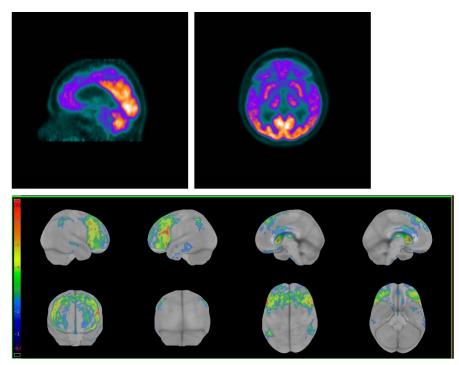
Metabolic pattern of amyotrophic lateral sclerosis on FDG-PET. Representative sagittal and axial PET images (upper pictures) show hypometabolism in the prefrontal and premotor cortex associated with symmetric relative hypermetabolism in the occipital cortical pole and in the cerebellum, z-score images (lower picture) confirm significant hypometabolism in the prefrontal and premotor cortex showing all pixels with a deviation below the mean of the normal controls in number of standard deviations (cut-off value -2 SD), quantitative software: CortexID Suite GE Healthcare[®], pons as reference region
